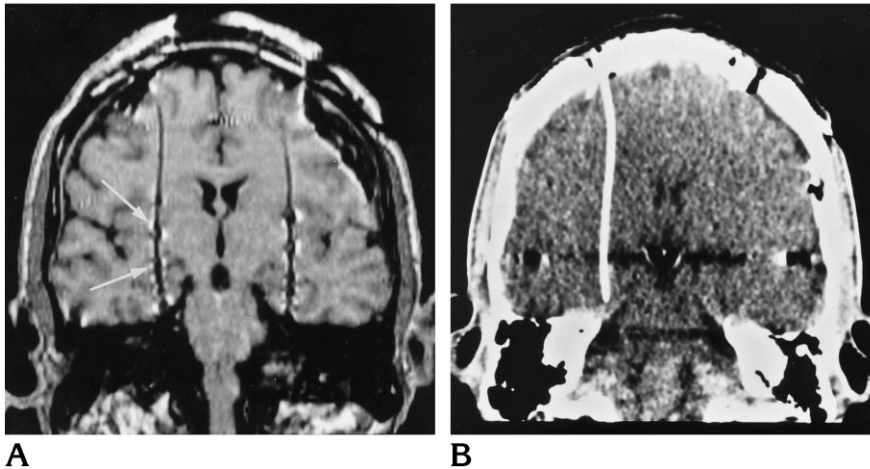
A, Coronal reformatted T1-weighted fast spin-echo MR image (550/13) shows the trajectory of the depth electrodes. The six contact points are well demarcated owing to a local increase in susceptibility artifacts (arrows).
